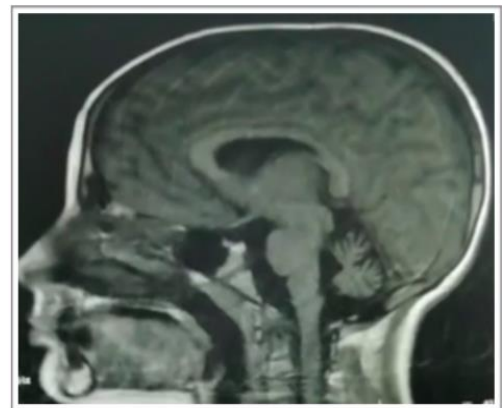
Atrophy was observed in the inferior part of both cerebellar hemispheres at cranial magnetic resonance imaging
